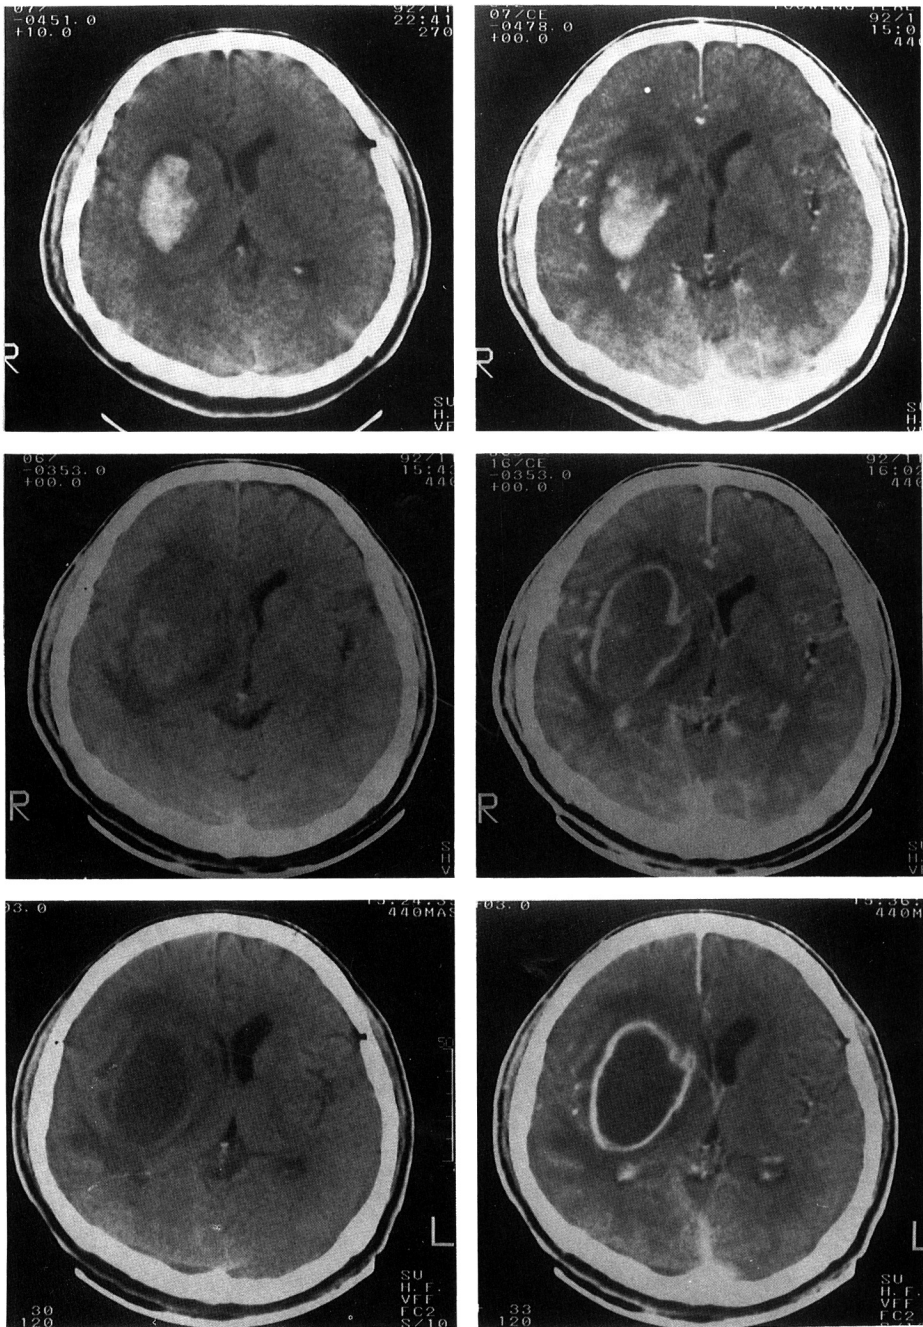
Serial CT scans before aspiration. Upper left : an immediate CT scan after the motorcycle accident. Upper right : a contrast enhanced CT scan three days after head injury. Middle : pre-(left) and post-(right) enhanced CT scans three days after spiking fever. Lower : pre-(left) and post-(right)enhanced CT scans 19 days after spiking fever.
